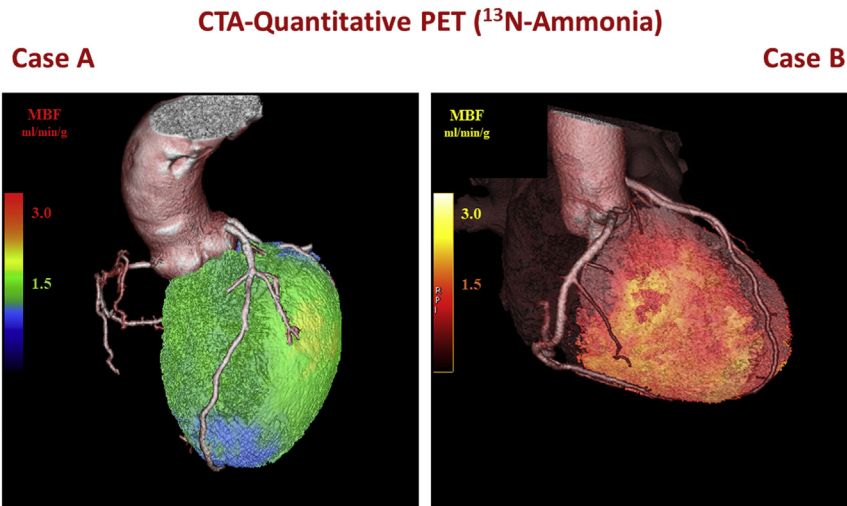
CTA-PET imaging. CTA-PET imaging in two patients with recent onset dyspnea. Case A is a 67 years old man with multiple risk factors, LBBB, systolic LV dysfunction (LVEF 30%), and diffuse non-obstructive CAD at CTA. Case B is a 60 years old man with glucose intolerance, mild hypertension, systolic LV dysfunction (LVEF 33%), and normal coronary arteries at CTA. In both cases, quantitative hyperemic (after i.v. dipyridamole) myocardial blood flow values with N-13 ammonia PET are globally reduced (normal values > 2 mL/min/g, please note different color codes have been used in these cases) (see also Ref.²¹ Liga et al. and Ref.²⁴ Neglia et al.).
